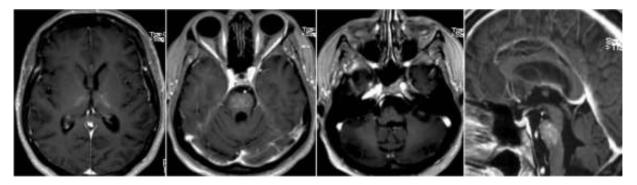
Post-gadolinium axial and sagittal T1w images at the same levels 1 week after the beginning of corticosteroid therapy. MRI examination revealed a reduction in number and size of contrast-enhancement foci within basal ganglia and midbrain, with a complete regression of enhancing nodules in cerebellar hemispheres and pedicles.
